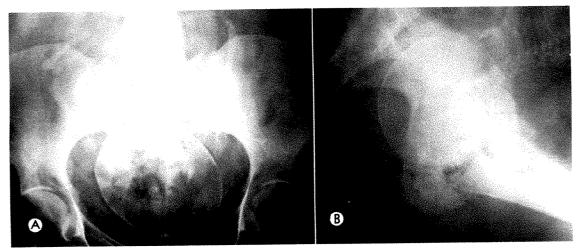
Case 1. (A) Anteroposterior roentgenogram showing numerous small, ovoid radiolucencies above and below the symphysis pubis. (B) Lateral view of pelvis demonstrates a long, thin, crescent shaped collection of gas below the engaged fetal head extending from the symphysis to the presacral region. Isolated cystic spaces are noted anteriorly.
